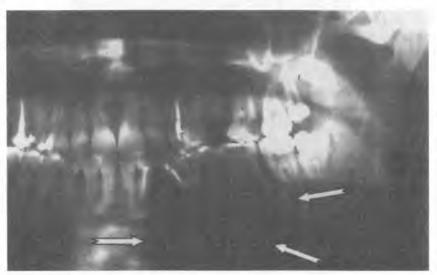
Panoramic X-ray demonstrates multilocular radiolucency in left mandibular body (arrows)
